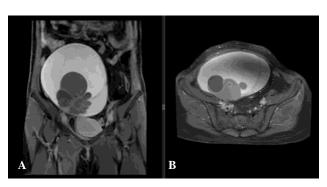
(A) Coronal T2-weighted MRI showing a large, multiloculated cystic pelvic mass with multiple septations and solid components arising from the adnexa, suggestive of a malignant ovarian neoplasm; (B) axial T2-weighted MRI depicting the same complex cystic lesion with irregular septae and areas of solid enhancement.
